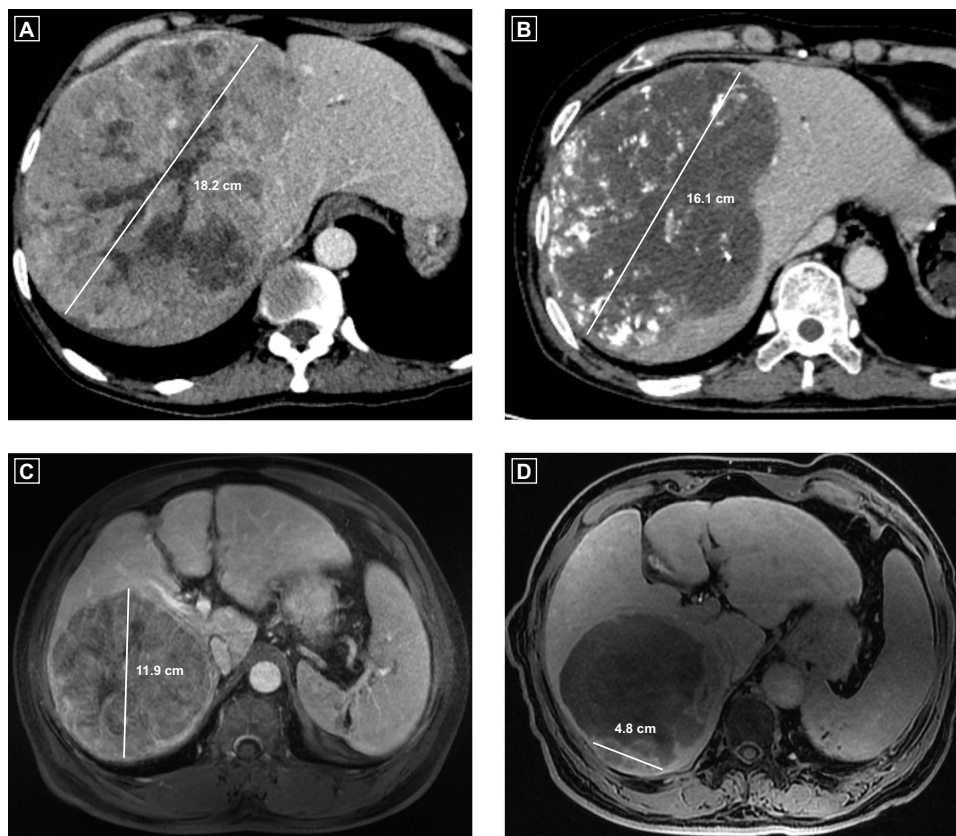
Images in a 59-year-old male (A and B) and a 68-year-old male (C and D) with initially unresectable hepatocellular carcinoma before and after combination therapy. For patient 1: (A) CE-CT showed a 18.2 cm single HCC, and (B) the lesion shrank to 16.1 cm (11.5%, RECIST 1.1: PR) and showed no enhanced portion (100%, mRECIST: CR) after combination therapy, AFP level decreased from 349.1 to 8.2 ng/mL (97.7%). The patient was determined as dual-positive responders, and post-resection pathology found <1% of residual viable tumors. He was still alive and did not develop tumor recurrence at the end of follow-up. For patient 2: (A) MRI found a 11.9cm single HCC, and (B) the lesion shrank to 11.1 cm (6.7%, RECIST 1.1: SD), with an enhanced portion of 4.8 cm (59.7%, mRECIST: PR), and AFP level decreased from 585.0 to 65.2 ng/mL (88.9%). The patient was determined as no responders and pathology found 30% of residual viable tumors. The patient experienced tumor recurrence 6.6 months after liver resection.
